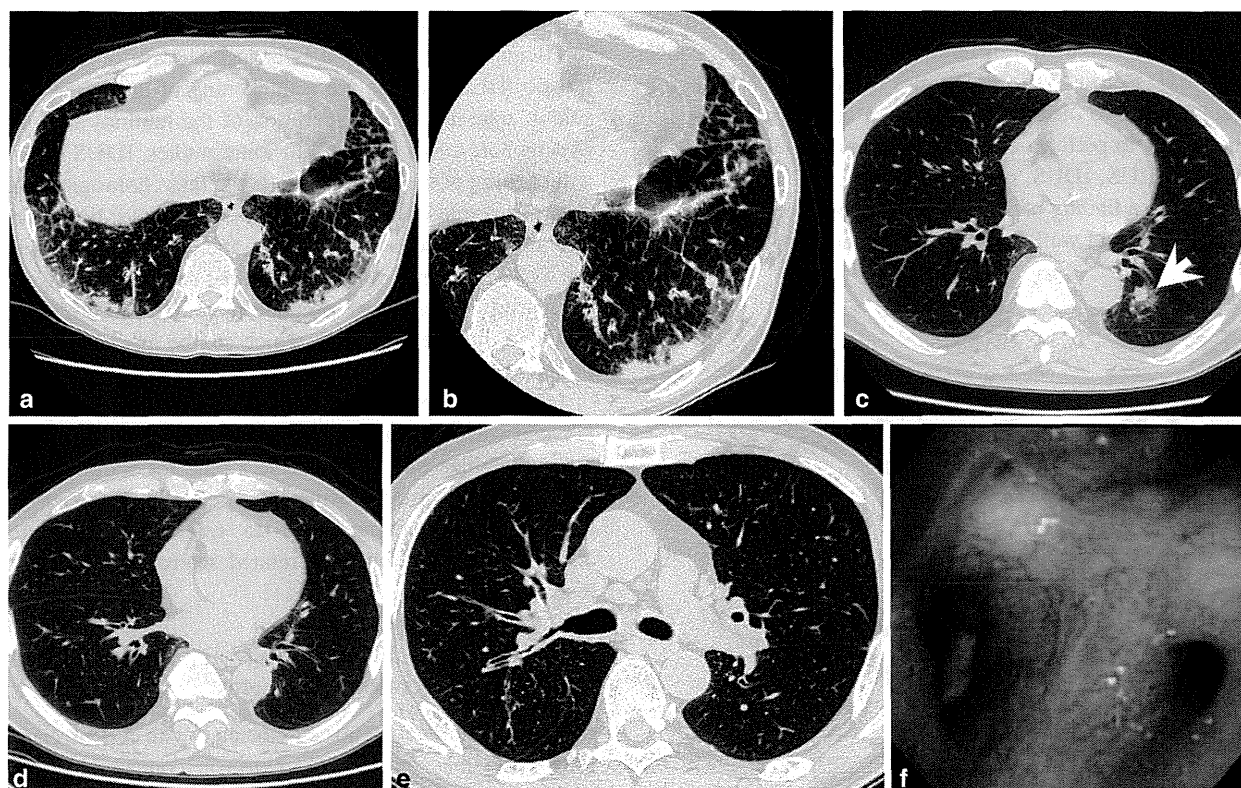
Various lung lesions associated with AIP. CT shows various lung lesions associated with AIP. a, b Bronchial wall thickening, a nodule, interlobular thickening, and infiltration in the lower lung field. CT shows nodular lesion identified as an inflammatory pseudotumor (*arrow*), c before corticosteroid therapy, d after therapy, the nodular
